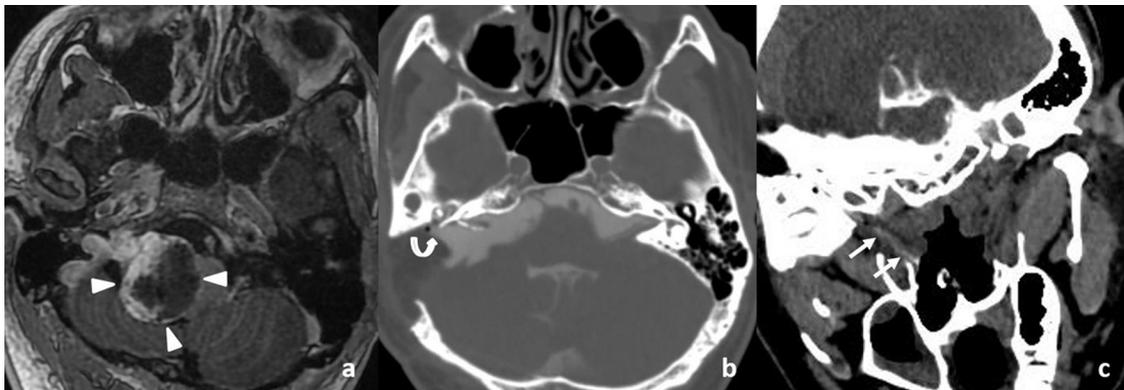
Thirty-year-old man with watery nasal discharge on right side, 2 months after surgery for non-vestibular schwannoma: a: presurgical axial post-contrast T1-weighted MR image shows heterogeneous enhancing mass in right cerebello medullary cistern abutting and displacing the brain stem (arrow heads); b: Post surgical axial CT cisternography image shows a bony defect involving the posterior aspect of the mastoid temporal bone with contrast opacified CSF extending into the epitympanum through a defect (curved arrow); c: post surgical coronal CT cisternography image shows opacification of the right eustachian tube with leakage anterior to the torus tubarius (arrows).
